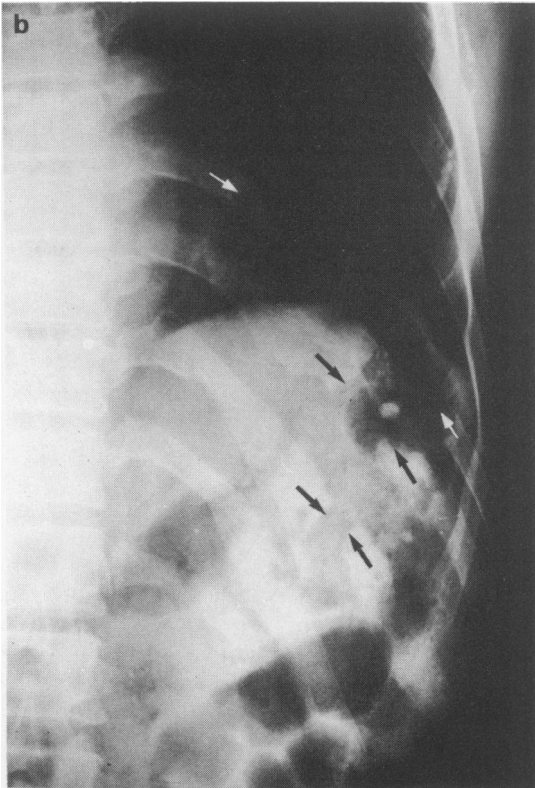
(a) Plain chest radiograph showing destruction of the lower left ribs with partial herniation of the splenic colon through a defect in the left hemidiaphragm. (b) Close up view of the left lower ribs showing severe destruction of the middle third of the left 8th, 9th and 10th ribs (arrows) with excessive periosteal new bone formations at the free ends of 9th and 10th ribs. Soft tissue calcification seen in the region of osteolysis. Note also the guinea-worm calcifications and the herniated colon.
